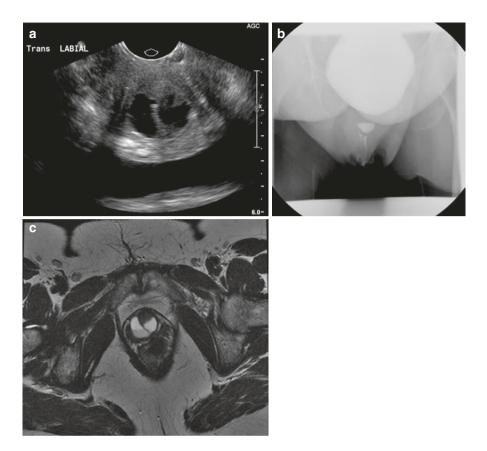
(a) Transvaginal ultrasound of a proximal saddlebag urethral diverticulum. (b) VCUG of a proximal urethral diverticulum. (c) Axial T2- weighted MRI of the same proximal saddlebag urethral diverticulum
